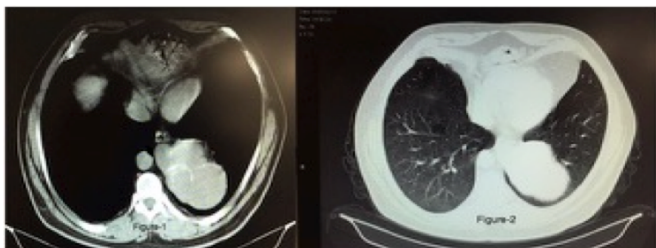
Thorax CT shows a lobulated, calcified, well-defined, homogenous soft-tissue density lesion with calcifications along the wall in the left posterior mediastinal region.
